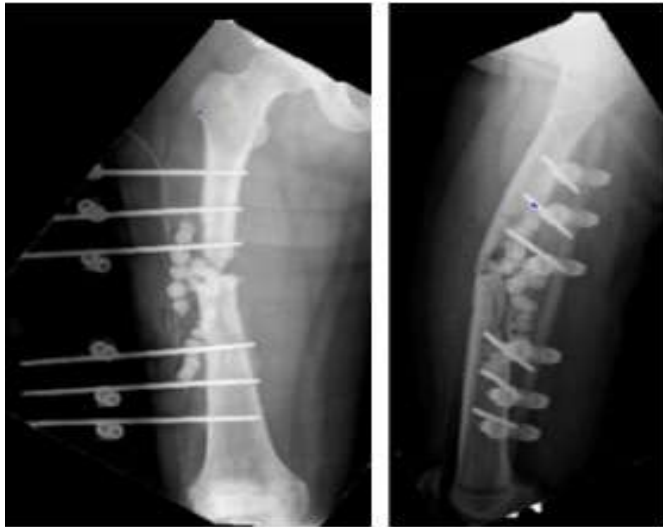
Post-operative X-Ray after debridement, application of antibiotic beads, and external fixation.
